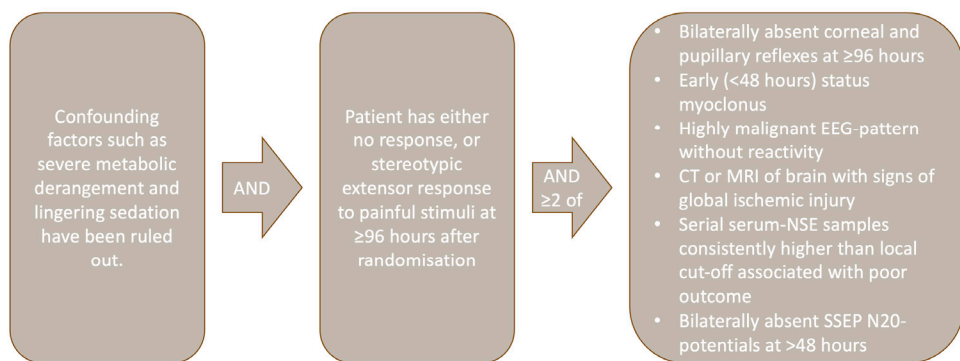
The TTM-2 criteria for a likely poor prognosis.¹⁷¹ EEG: Electroencephalogram. CT: Computed tomography. MRI: Magnetic resonance imaging. NSE: Neuron-specific enolase. SSEP: Somatosensory evoked potentials.
